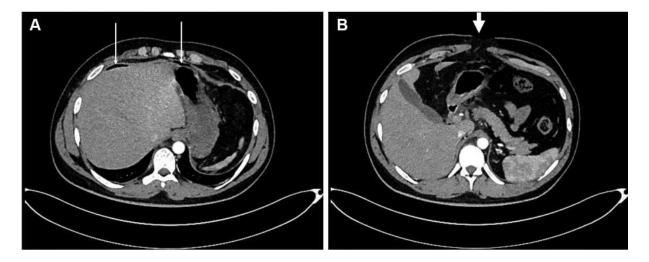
Computed tomography images of the abdomen. (A) Pneumoperitoneum (thin arrows). (B) The site and direction of the penetrating injury (thick arrow).
